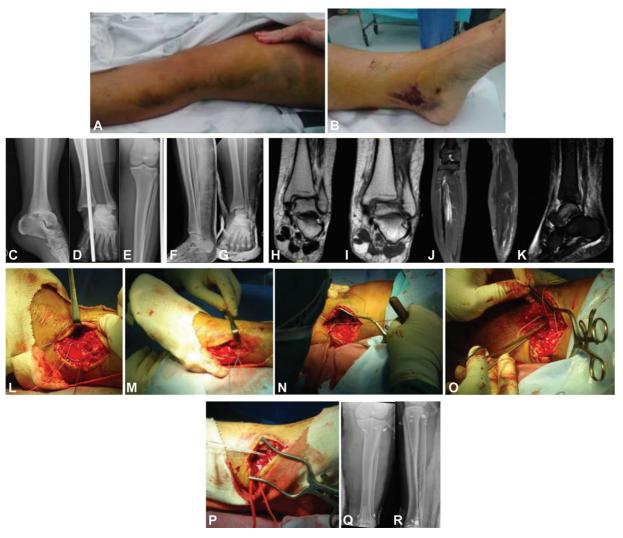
(A,B) Contusions on the external and internal sides of the knee. Similar injuries appeared on both sides of the ipsilateral ankle as well. (C-E) Pure tibiotalar dislocation without fracture. (F,G) Postreduction radiograph showing persistence of the widening of the tibiotalar joint (medial clear space). (H-K) Magnetic resonance imaging scan showing complete rupture of the ankle syndesmosis and the deltoid ligament, and, proximally, an external non-displaced tibial plateau fracture and an image suggestive of non-displaced fibular head fracture. (L) Repair of the distal syndesmosis with a TWINFIX implant. (M,N) Reduction of the distal and proximal syndesmosis withINVISIKNOT implants. (O) Repair of the collateral ligament and biceps tendon with a TWINFIX implant. (P) Repair of the deltoid ligament with another TWINFIX implant. (Q,R) Postoperative radiographs showing the reduction and maintenance through INVISIKNOT and TWINFIX implants.
